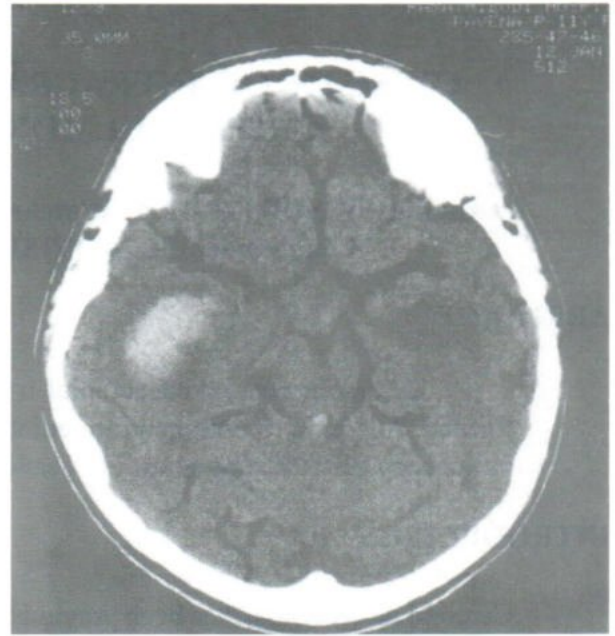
NCE CT scan of the brain showed air in the arteries of carotid and vertebrobasilar system of both sides, (hematoma is also noted in right temporal lobe, and in the 4th ventricle)
